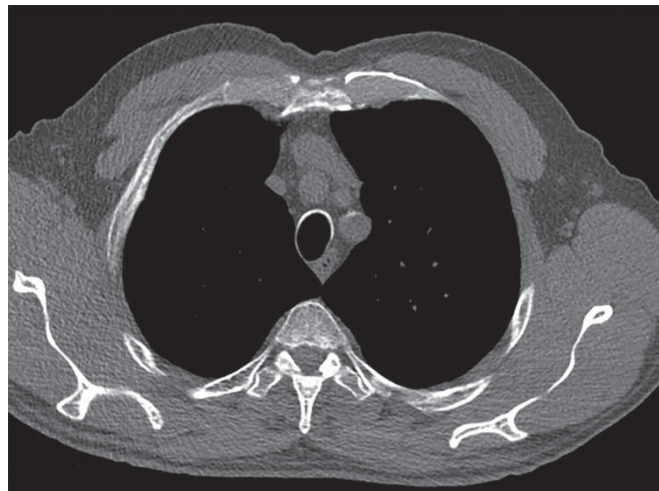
A computed tomography slice at the level just above the aortic arch.
